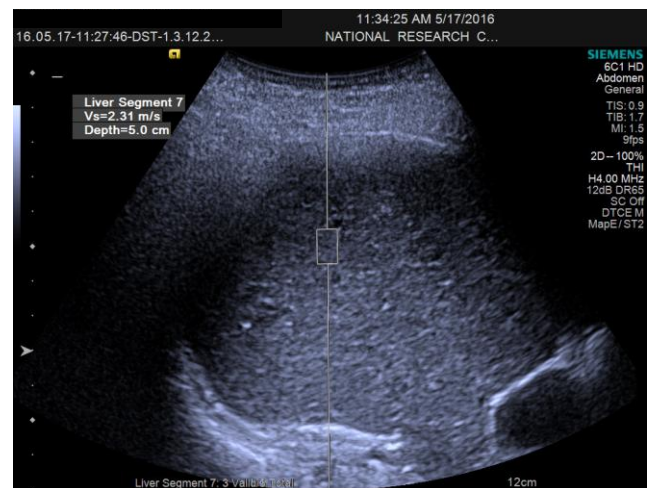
Ultrasonographic picture of ARFI examination for liver fibrosis
